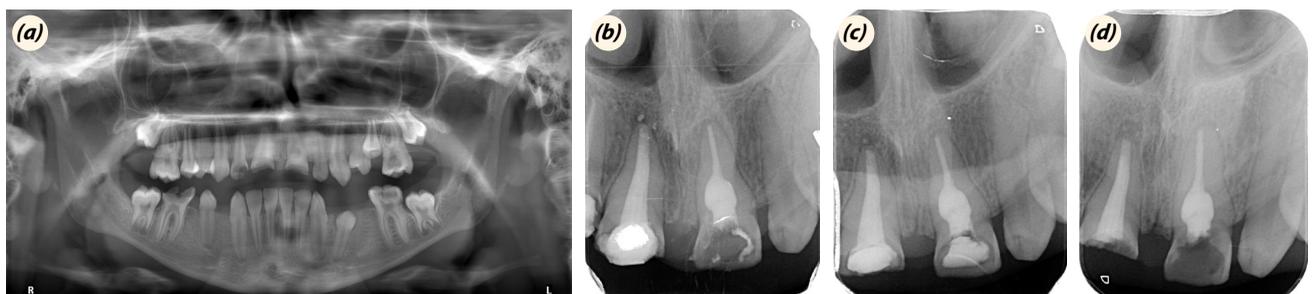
Case 1, (a) initial, (b) post-treatment radiograph, (c) 1 year follow-up, (d) 3 year follow-up.
